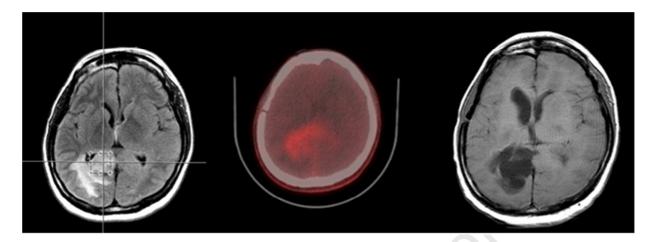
Imaging Results for Patient 10. (Left) Magnetic Resonance Imaging (MRI) showed a viable tumor in the right occipital lobe. (Middle) The 4-borono-2-18F-fluoro-phenylalanine (FBPA) positron emission tomography (PET) image. The tumor-to-tissue (T/N) ratio was 2.0, which just reached the minimal requirement for Boron Neutron Capture Therapy (BNCT) treatment. (Right) MRI image 6 months after BNCT, showing significant shrinkage of the tumor.
